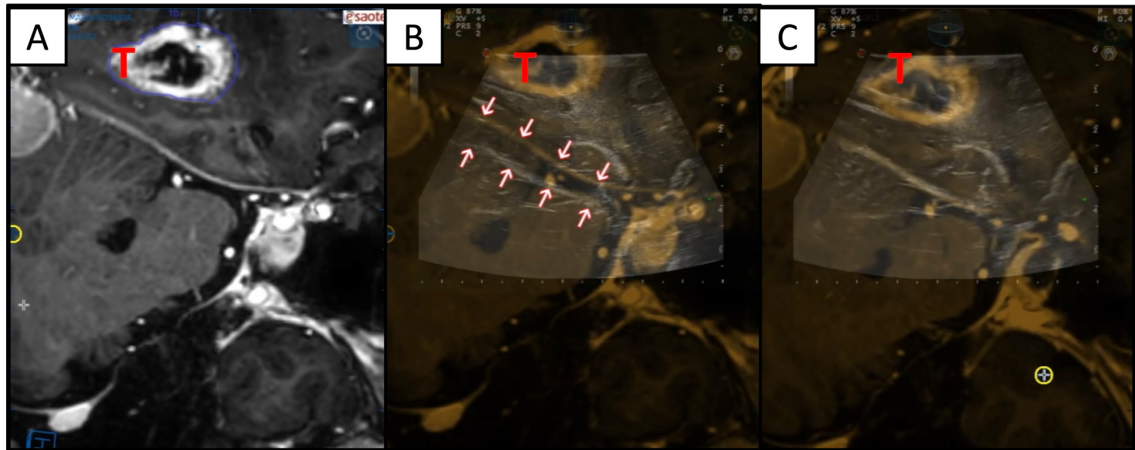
Brain-shift correction using modern combined ultrasound-neuronavigation systems.
